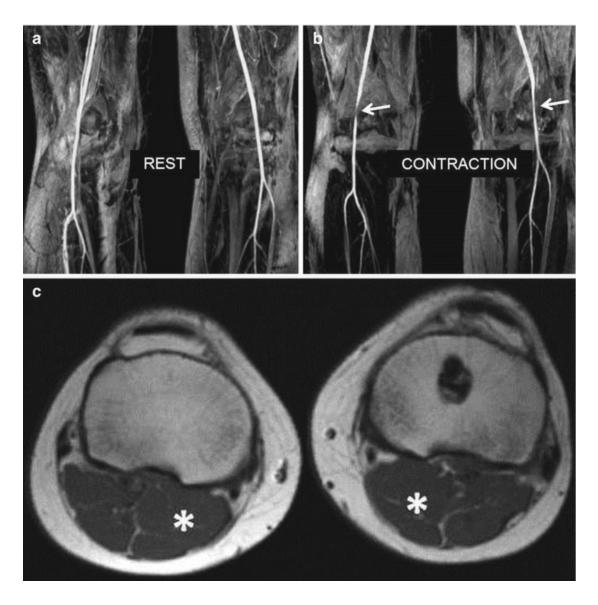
A 23-year-old female patient with a history of chronic leg pain on exertion and functional popliteal entrapment syndrome. Coronal MR angiography reformatted maximum intensity projection (a, b) demonstrate significant stenosis of the proximal popliteal artery (*arrows*) during contraction of the triceps surae. Axial T1-weighted MRI (c) of the popliteal fossa confirms mild hypertrophy of the proximal medial gastrocnemius muscles (*asterisks*)
